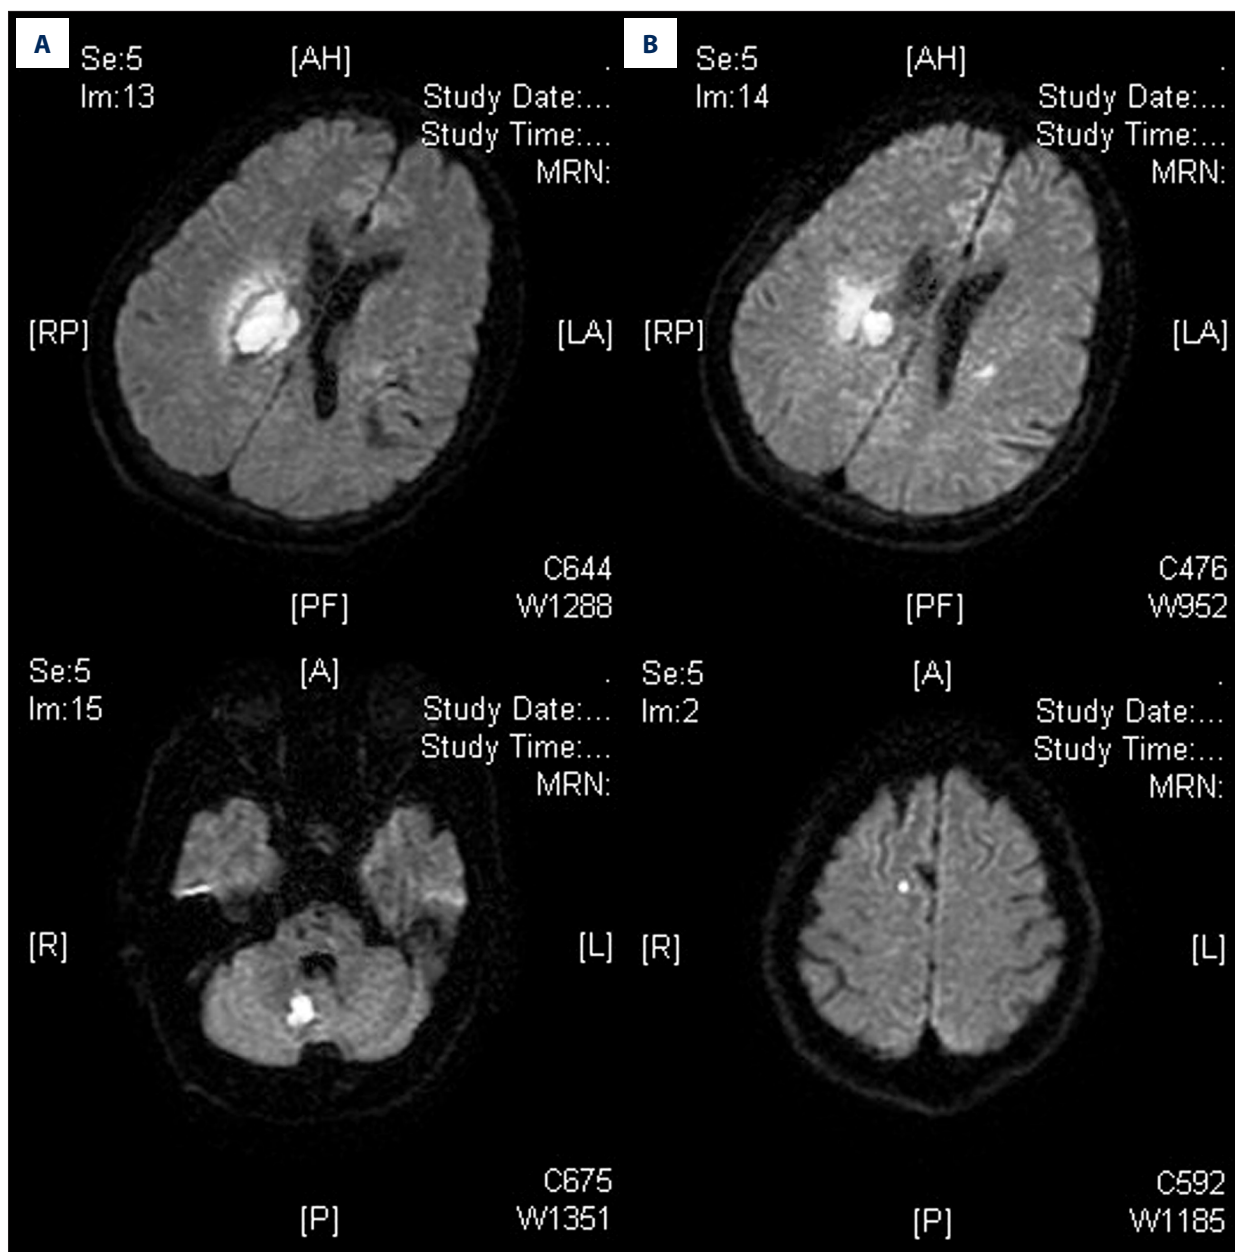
The diffusion-weighted imaging of magnetic resonance imaging (A is cerebral bleeds; B is silent cerebral infarction).
